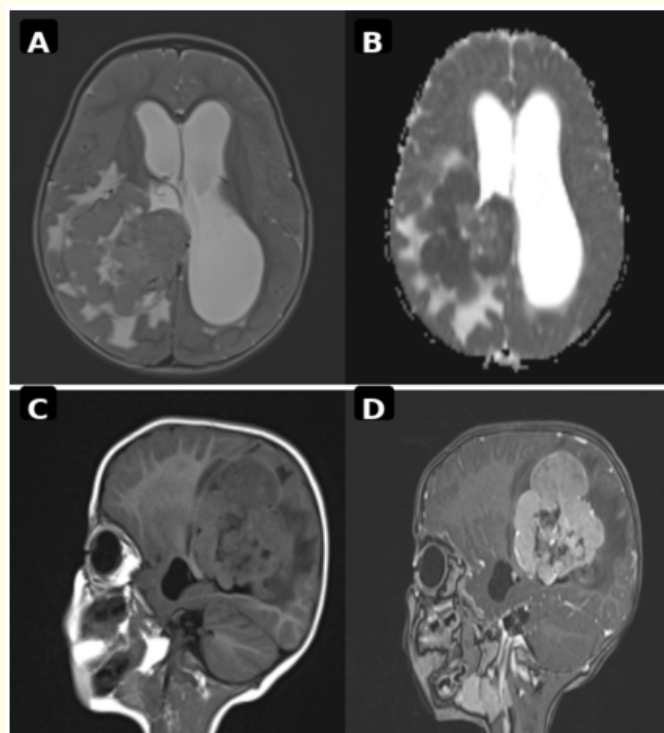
Brain MRI. Axial FLAIR (A) and sagittal T1-weighted (B) images depict a large lobulated intraventricular mass with heterogeneous signal, surrounding edema, marked hydrocephalus, and mass effect. Sagittal post-gadolinium T1-weighted imaging (C) shows intense heterogeneous enhancement. The ADC map (D) demonstrates heterogeneous low-ADC areas within the solid tumor component.
